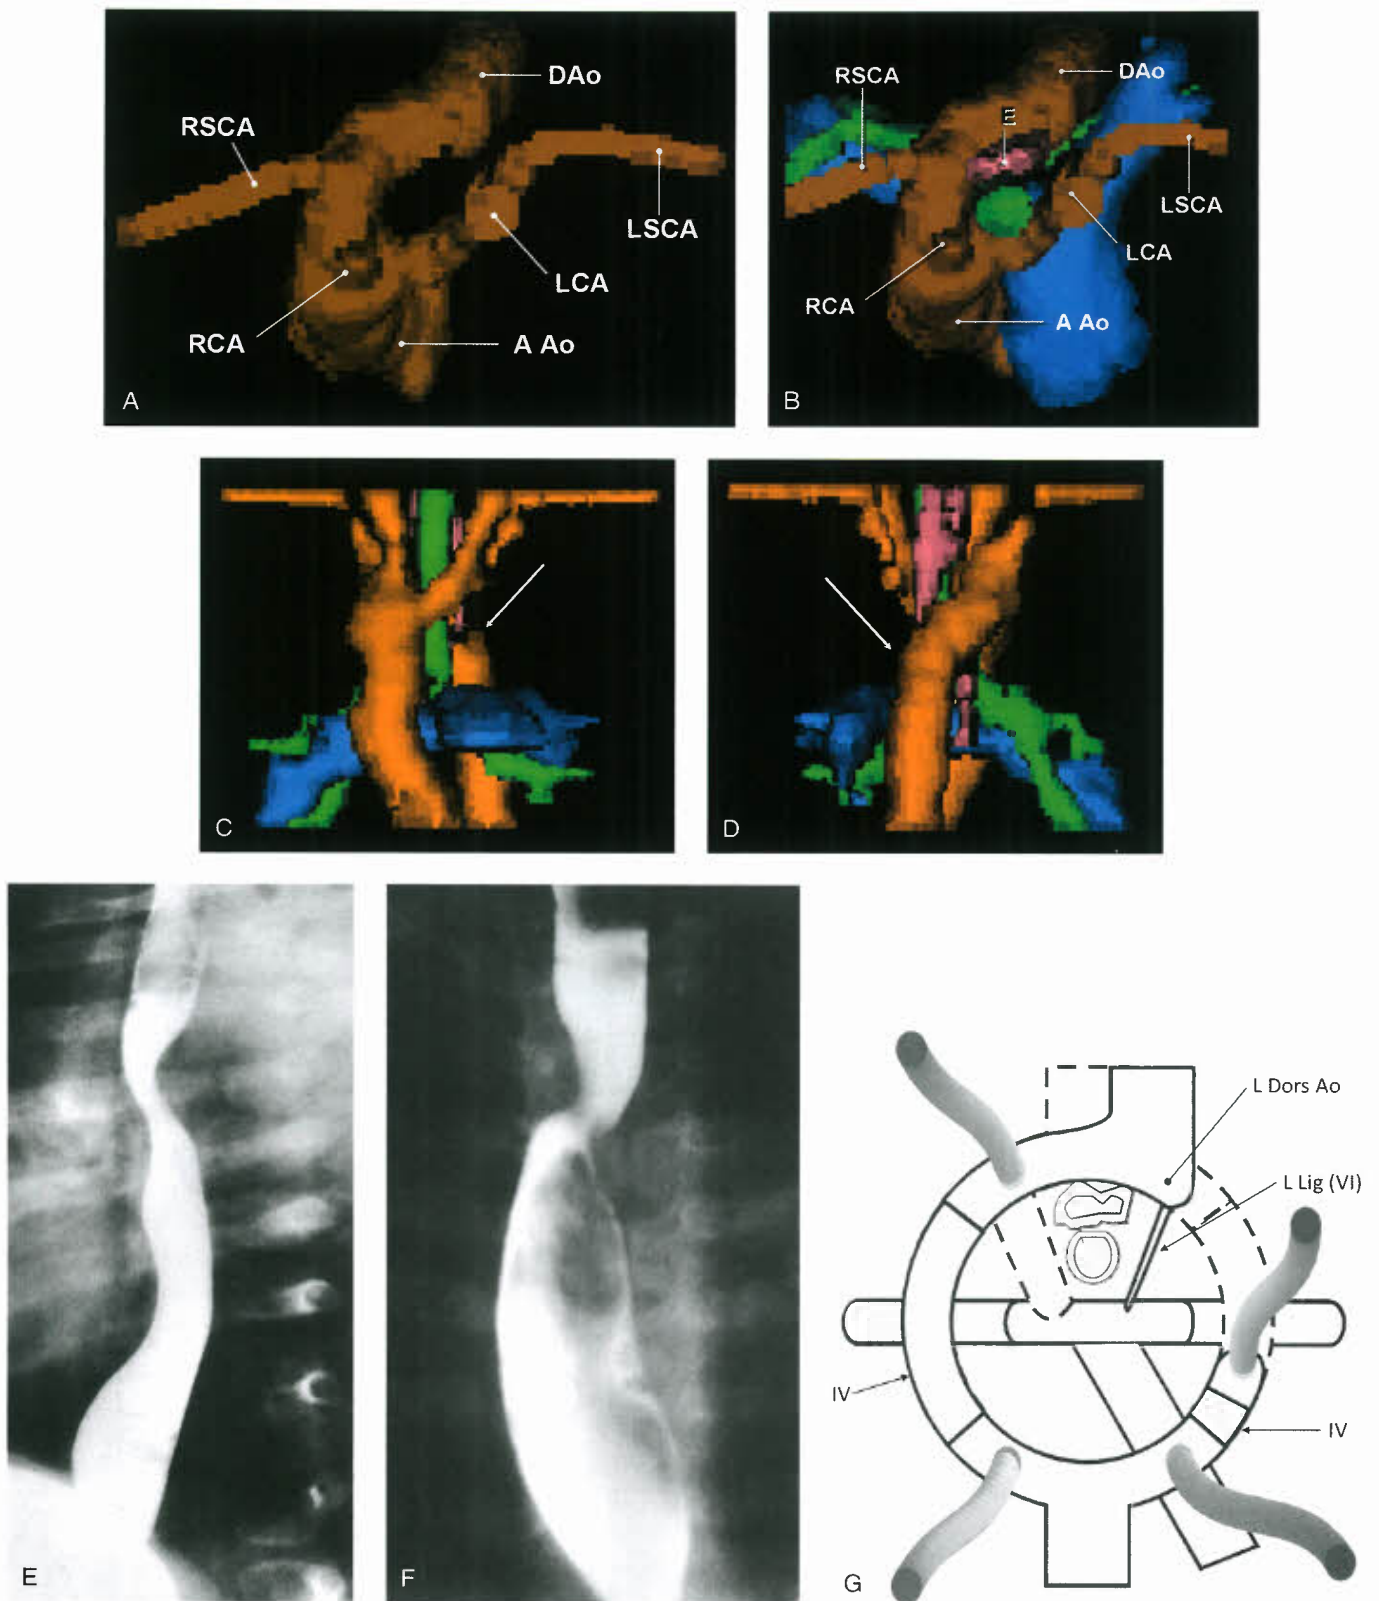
Right aortic arch, left descending aorta, left innominate artery. A: Cranial view of 3-D shaded surface display from MRI showing takeoff of brachiocephalic arteries: left innominate artery giving rise to LCA and LSCA, RCA, and RSCA. B: Same view as (A) but with trachea (green), esophagus (blue), and pulmonary artery (red) showing further crowding. Anterior (C) and posterior (D) of same reconstruction showing retroesophageal course of circumflex aortic arch with sharp turn inferiorly at point of attachment of ligamentum arteriosum (arrow) to descending aorta. Barium esophagram in lateral view (E) showing large posterior indentation, and AP view (F) showing bilateral indentations on the esophagus. Similar patterns are seen with double arch and right arch with diverticulum. G: Embryonic arch pattern similar to Figure 33.9D above but with left descending aorta instead of right.
